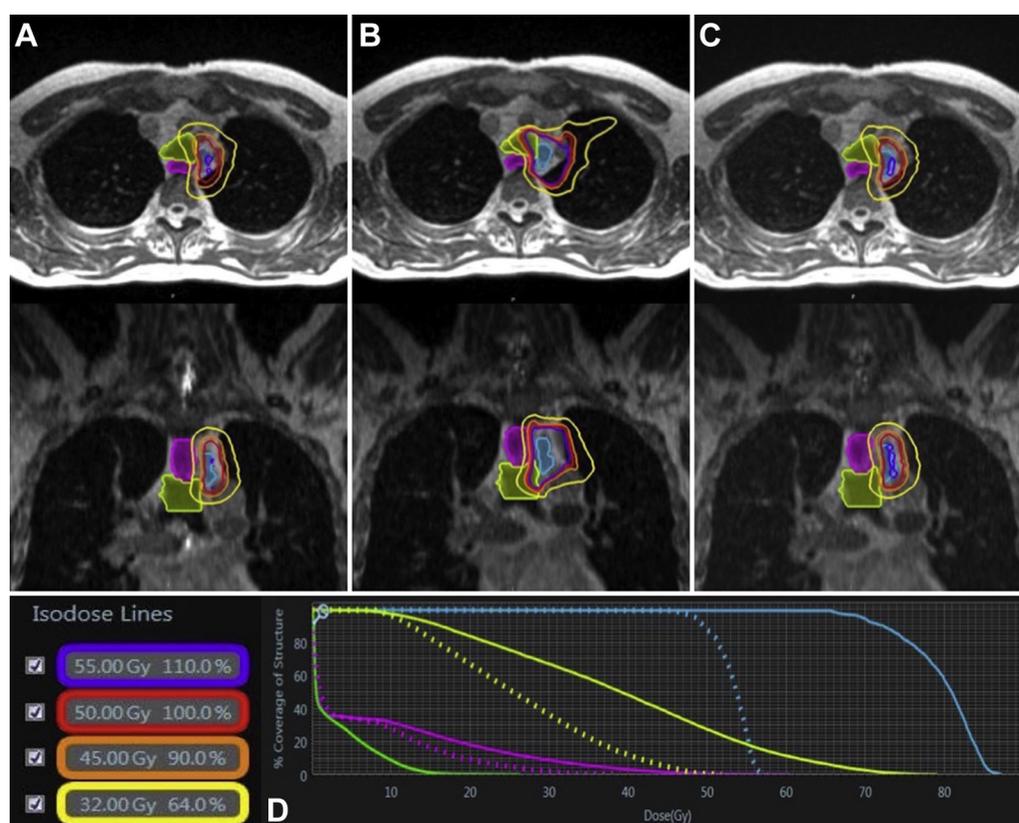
(A) A magnetic resonance (MR)–based, adaptive plan for fraction 1 (fx1) met all organ-at-risk (OAR) constraints based on daily setup anatomy from fx1. (B) Application of the fx1 plan to the fx2 MR image of a patient with an upper paratracheal metastasis (blue colorwash) abutting the esophagus (pink colorwash) resulted in violation of hard esophageal and trachea (green colorwash) constraints. (C) Daily adaptive planning for fx2 achieved OAR violation reversal while preserving target volume coverage, as determined by dose-volume histogram comparison (D). (A color version of this figure is available at <https://dx.doi.org/10.1016/j.adro.2018.10.003>.)
